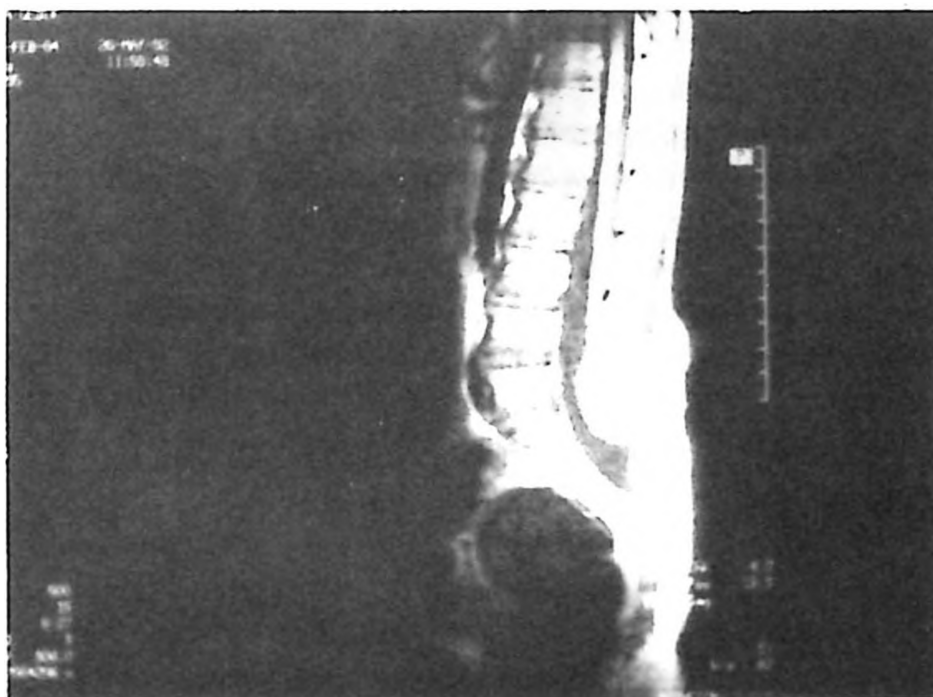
Sagittal T₁ weighted MR imaging showed lipomyomeningocele which displaced the conus and its neural attachments downward. (SE, TR 500, TE 15)
